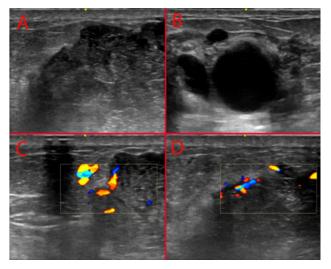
Ultrasound image of a mass of the mammary gland. A - The border of healthy and affected tissue; B - Multiple anechoic cysts of the mammary gland; C, D - the tumor is penetrated by large vessels.
